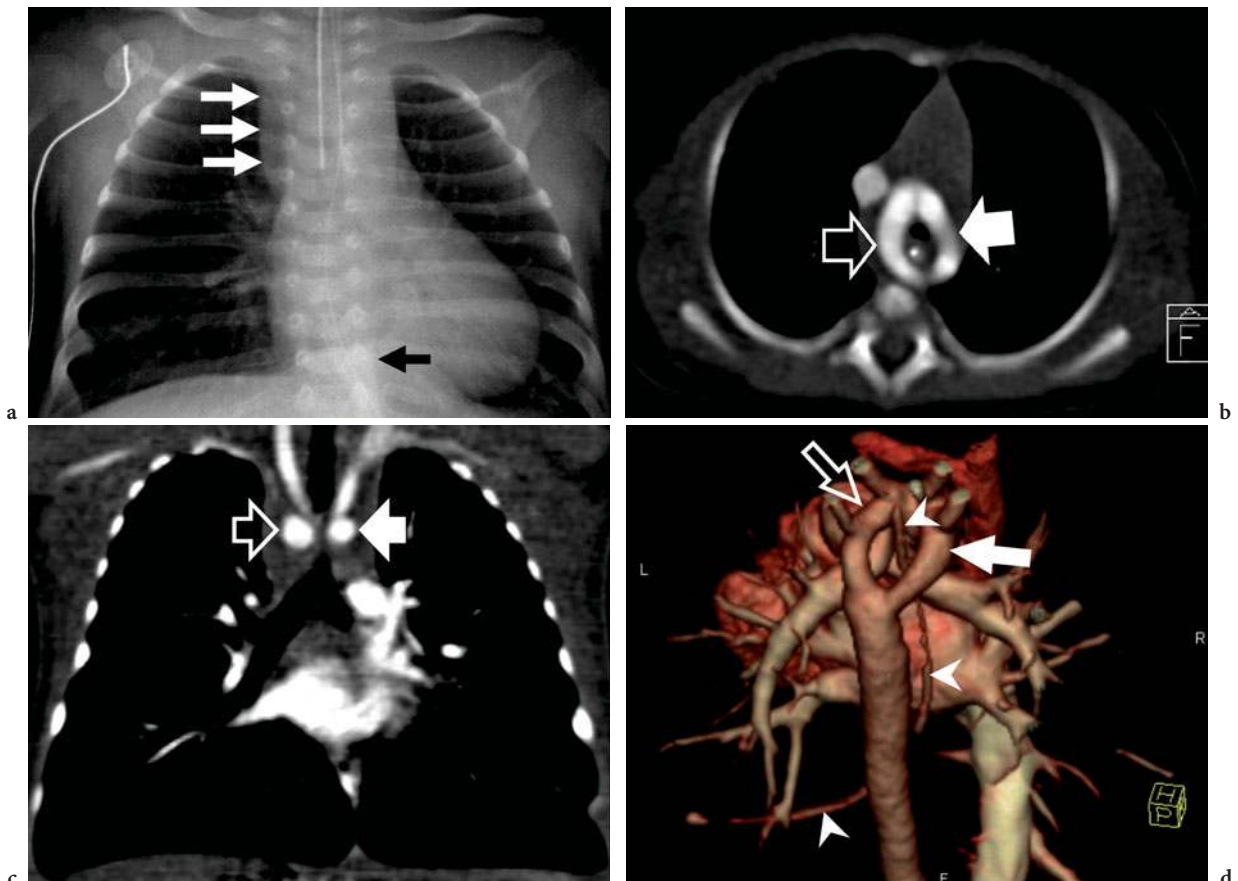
Balanced double aortic. a Chest radiograph in a 6-week-old neonate with stridor and respiratory failure requiring intubation. There is abnormal right paratracheal soft tissue (white arrows). The descending aorta is left sided (black arrow). b Axial, and c coronal CT reconstructions demonstrating a double aortic arch (open arrow right arch, white arrow left arch) of approximately equal size, encircling the narrowed trachea and oesophagus (a nasogastric tube is in situ). d Volume rendered 3D reconstruction: view from right postero-superior position: the nasogastric tube (arrowheads) runs between the right (white arrow) and left (open arrow) aortic arches
